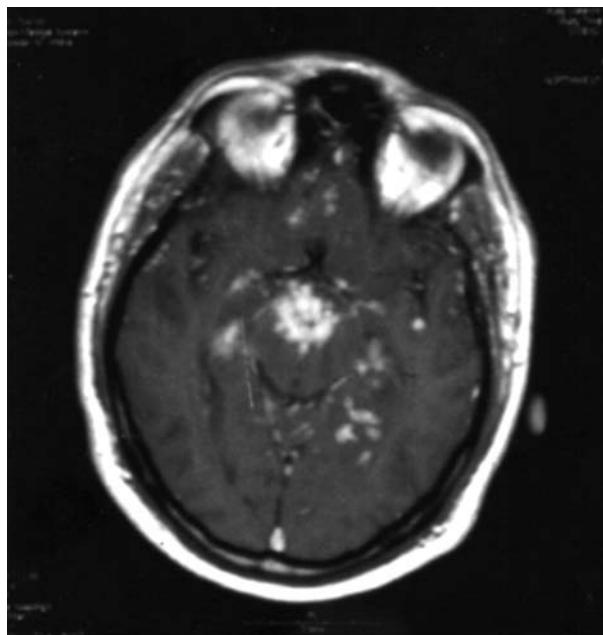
MRI brain showing extensive leptomeningeal enhancement and involvement of the hypothalamus.
